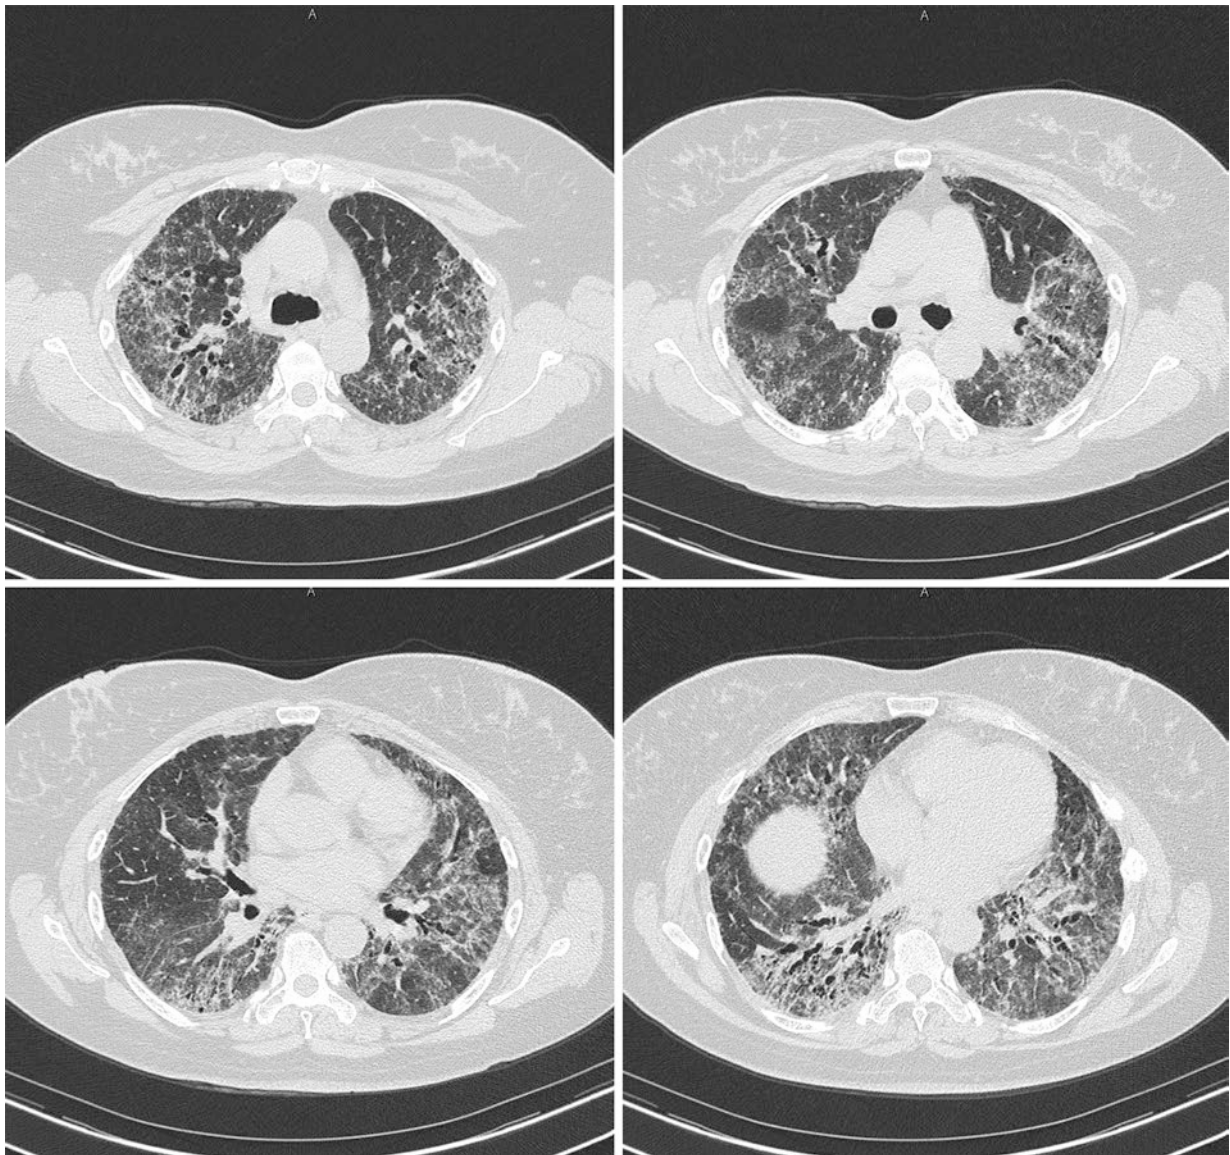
High resolution computed tomography (HRCT) scan of the chest showing bilateral airway-based ground glass opacities with mosaic attenuation, reticulation, and traction bronchiectasis involving all lung zones
